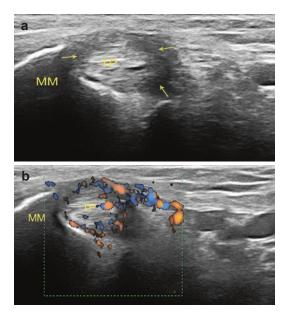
(a) Tibialis posterior (*TP*) tenosynovitis (*arrows*), (b) in power Doppler. *MM* medial malleolus
